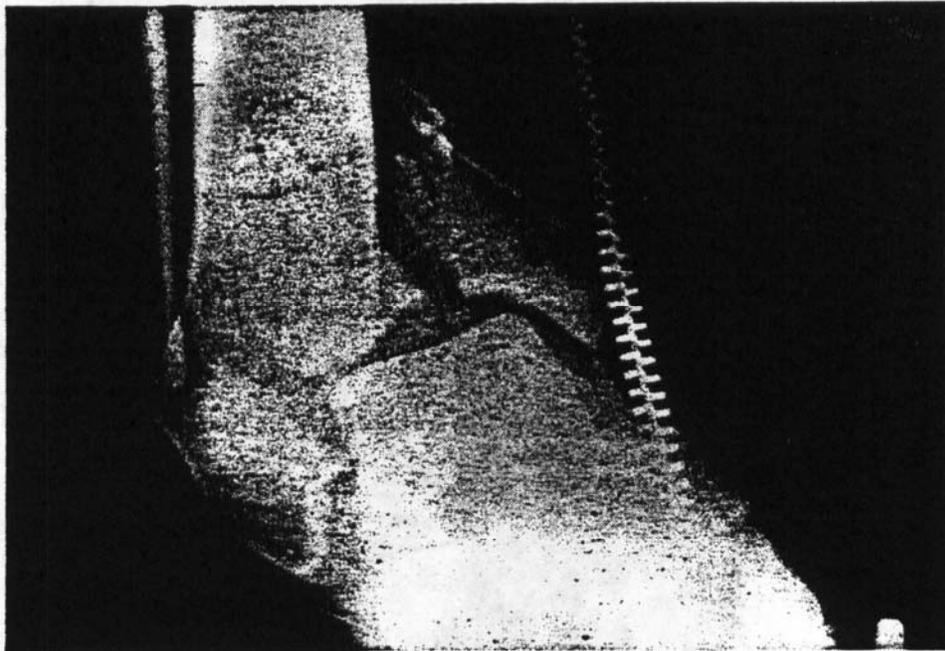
X-ray of patient's right ankle showing a trimalleolar fracture-dislocation. Pt sustained identical injury in other ankle.
